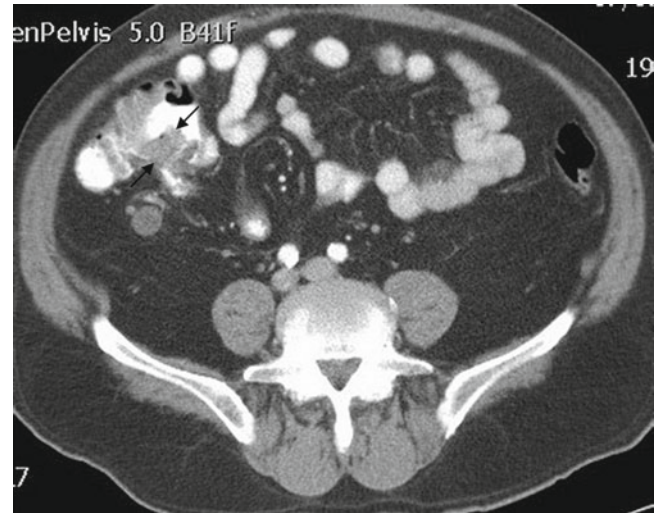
A 77-year-old man with iron deficiency anemia. Axial oral and intravenous contrast enhanced CT image through the lower abdomen shows a mass in the cecum (*black arrows*). Diagnosis: Cecal carcinoma
